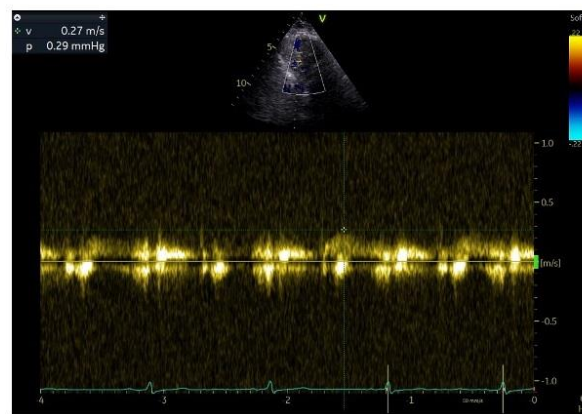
A typical color-flow appearance for a M-LAD: 3a from apical 3-chambers approach; 3b from parasternal short axis approach; 3-c s pulsed-wave Doppler CFV envelope. The M-LAD tract runs up to the insertion of the tip of right ventricle on the interventricular septum. To obtain a good color-PW Doppler signal from M-LAD are needed about 1–2 minutes
